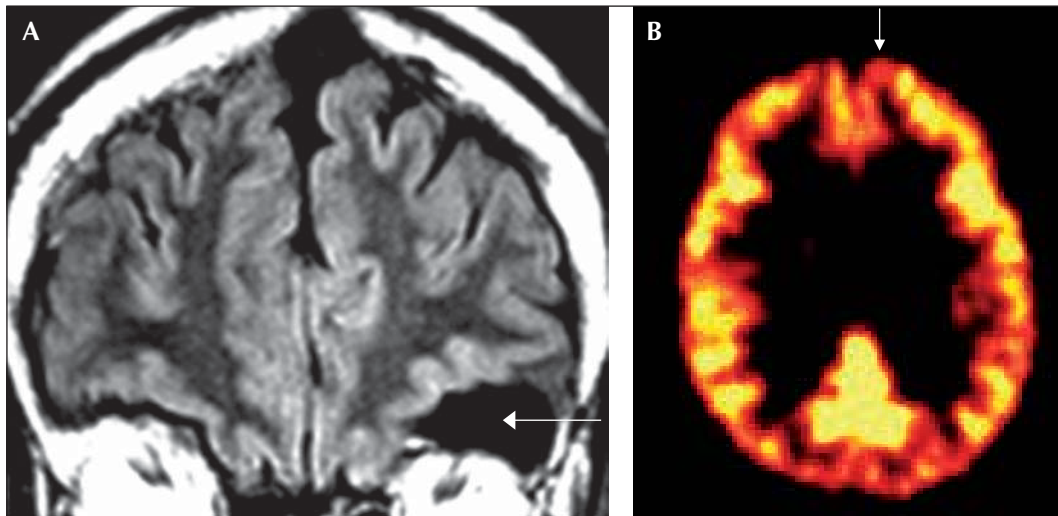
Neuroimaging in patient 2: A) MRI shows a left fronto-basal arachnoid cyst; B) interictal [^{11}C]Flumazenil-PET demonstrate left mesial frontal decreased benzodiazepine receptor density.
